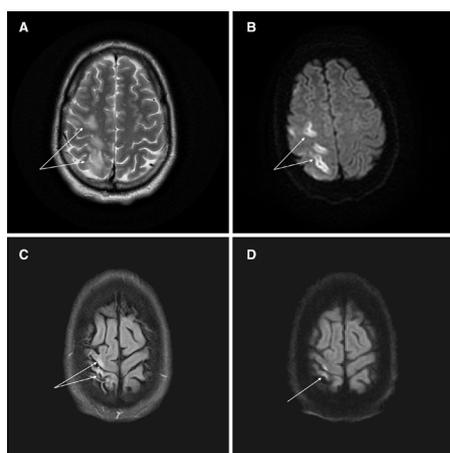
MRI brain images of case 4, one of the patients presenting with neurological events, which were not consistent with a single vascular territory stroke—initial presentation: two images (1) T2-weighted image: precentral and postcentral gyrus ischaemia (A). (2) Diffusion-weighted image: precentral and postcentral gyrus ischaemia (B). Subsequent presentation: two images (1) diffusion-weighted image: precentral and postcentral gyrus ischaemia (C). (2) FLAIR image: precentral and postcentral gyrus ischaemia (D). FLAIR, fluid-attenuated inversion recovery image.
